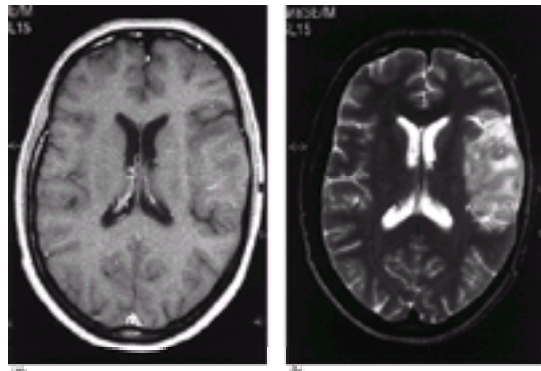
Astrocytoma. (a) Axial T₁-weighted gadolinium-enhanced MRI of a left frontotemporal tumor. There is no contrast enhancement or mass effect. The cortex of the sylvian fissure and insula have decreased signal intensity compared to the right side. (b) T₂-weighted axial image of the same tumor with a well demarcated area of increased signal in the lateral insula and temporal lobe.
